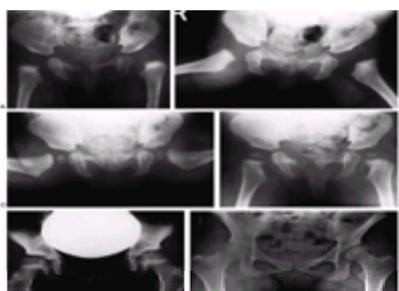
A 4-month-old white girl with left hip dislocation and right hip subluxation. A: Anteroposterior (AP) view. B: Abduction view. C: Abduction view at 7 months of age, 3 months after closed treatment. D: AP view at 7 months of age, 3 months after closed treatment. E: AP view at 7 years of age. Note the mild anatomic dysplasia of both hips. F: AP view at 15 years of age. Note the bilateral anatomic dysplasia. The right hip is radiographically dysplastic, and the left hip is
